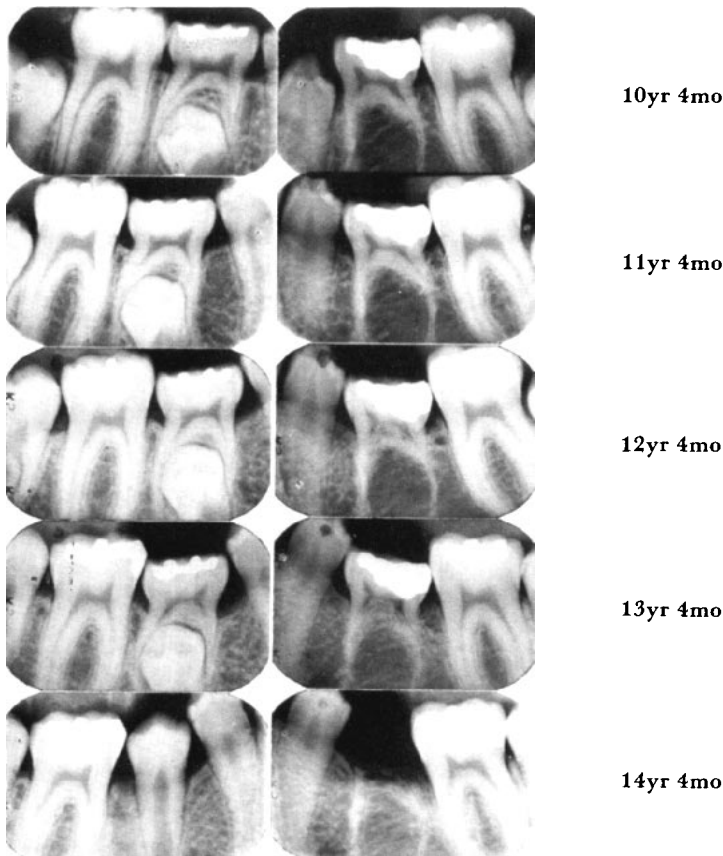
Periapical radiographs of a boy from 10yr 4mo to 14yr 4mo of age. Both second deciduous molars showed progression of the infraocclusion (left side 3.4mm→4.7mm). The infraoccluded deciduous molar with no successor was extracted at 13yr 4mo of age; note the residual root fragments one year later.
